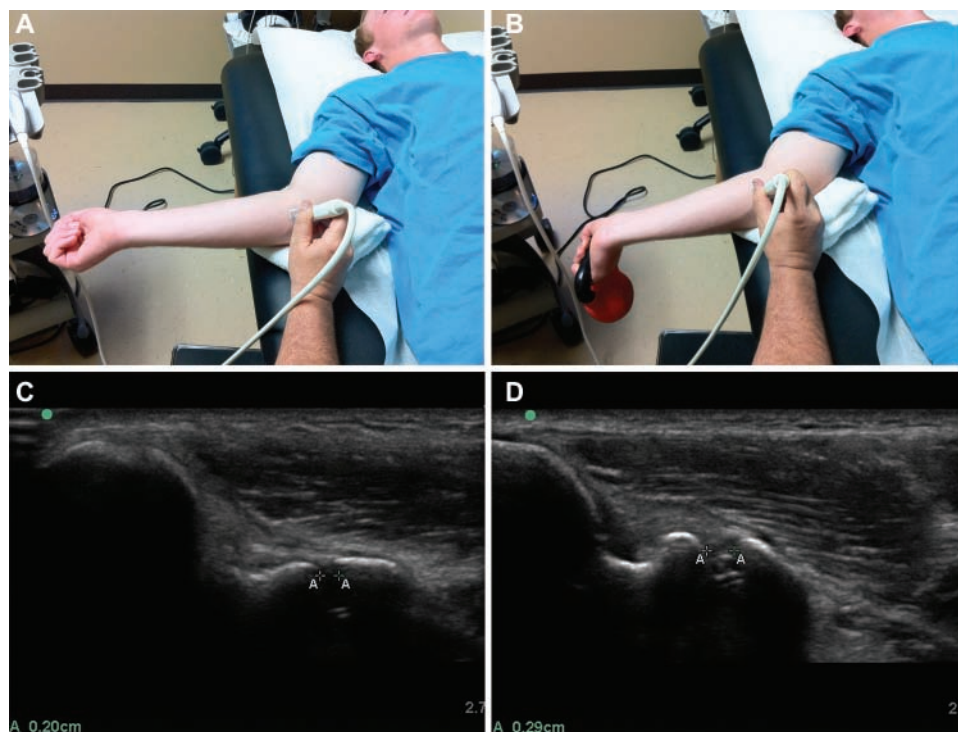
Each patient underwent ultrasound measurement of the medial elbow joint space: (A) without valgus stress and (B) with 10 lb of valgus stress on the elbow. The ultrasound images show ulnar collateral ligament and humeral-ulnar joint measurements (C) without valgus stress and (D) with 10 lb of valgus stress.
